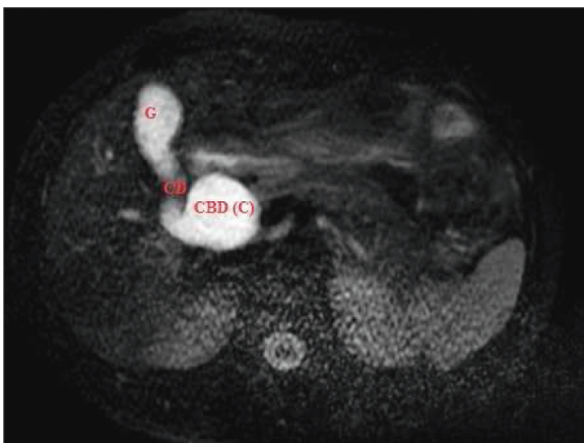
Gallbladder (G), cystic duct (CD) and choledoch (C) in the axial magnetic resonance imaging image.
